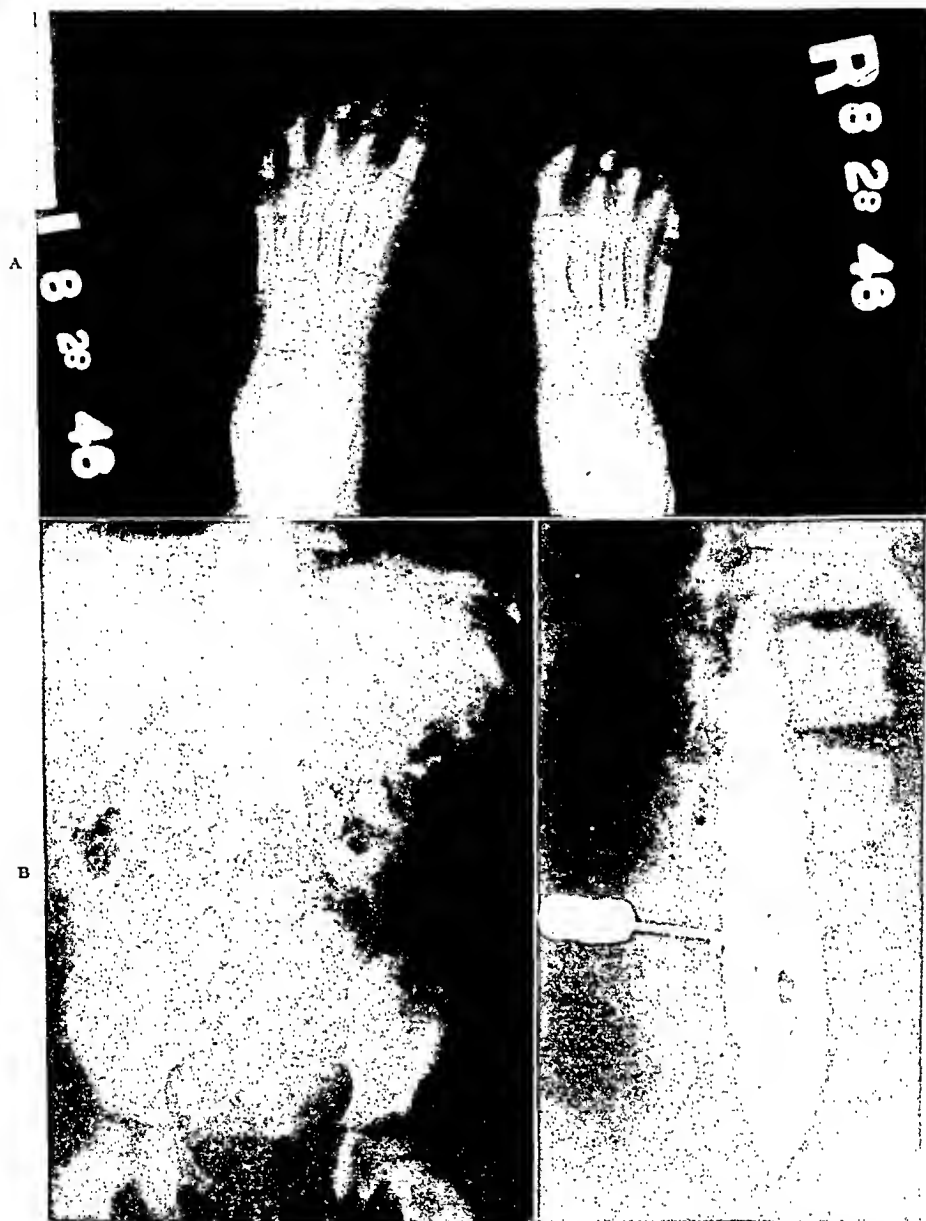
A, photograph of roentgenogram of the feet of a patient aged one and one-half years born with a lumbar, sacral and coccygeal spina bifida occulta. Note the underdevelopment of the right foot as compared with the left. B, photograph of roentgenogram revealing the spina bifida occulta. C, pantopaque myelogram revealing abnormal bony spinule situated in the midline at L3. At operation this was found to be adherent to and impinging upon the right half of the cauda equina.
